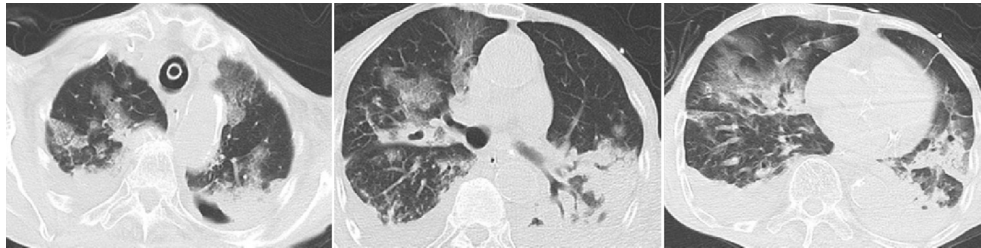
Klebsiella pneumoniae* and *Staphylococcus aureus* co-infected pneumonia in an 89 years old man with MV for severe pneumonia and hypoxemic respiratory failure. CT images show multiple patchy GGOs and consolidation with bronchocentric distribution in both upper lungs and diffuse distribution in left lower lung. Several cavities can be seen in regions of consolidation.
